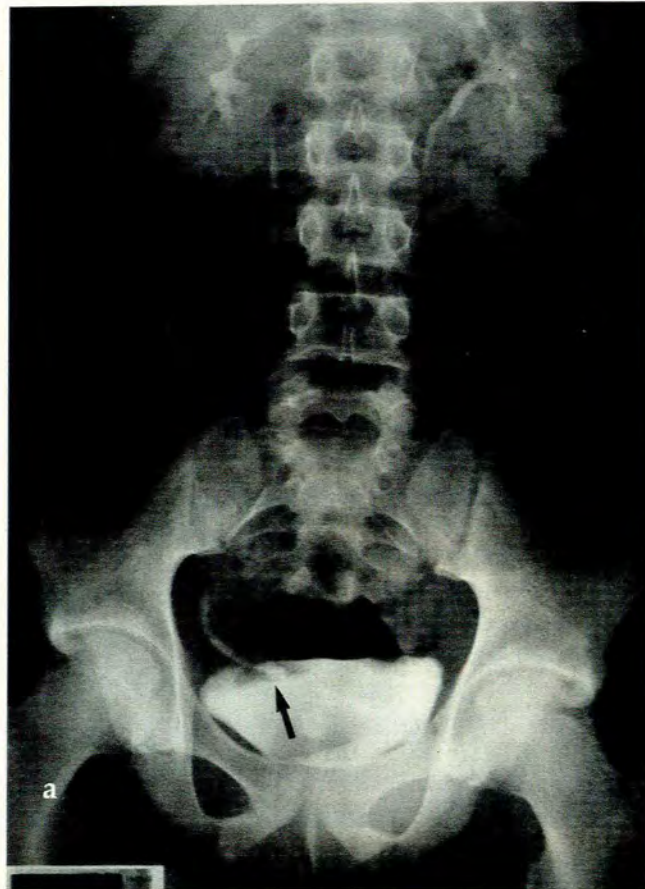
Conventional (a) and digital (b) abdominal radiographs following intravenous pyelography, demonstrating a filling defect (arrow) at the right ureterovesical junction. Note the poorer demonstration of the pelvic bony detail on the digital image.
